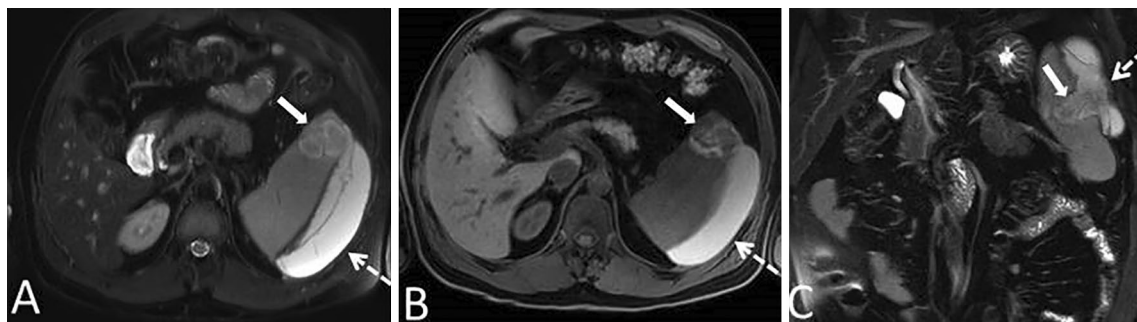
44-year-old male patient presenting with acute left upper quadrant pain. On US, hypoechoic subcapsular fluid collection encircling the spleen and an intraparenchymal mass of heterogenous echotexture were found (not shown). Axial T2W (A) and precontrast fat-saturated T1W (B) MR images show subcapsular splenic hematoma (dashed arrows) and a hemorrhagic lesion (arrows) in the spleen. C
